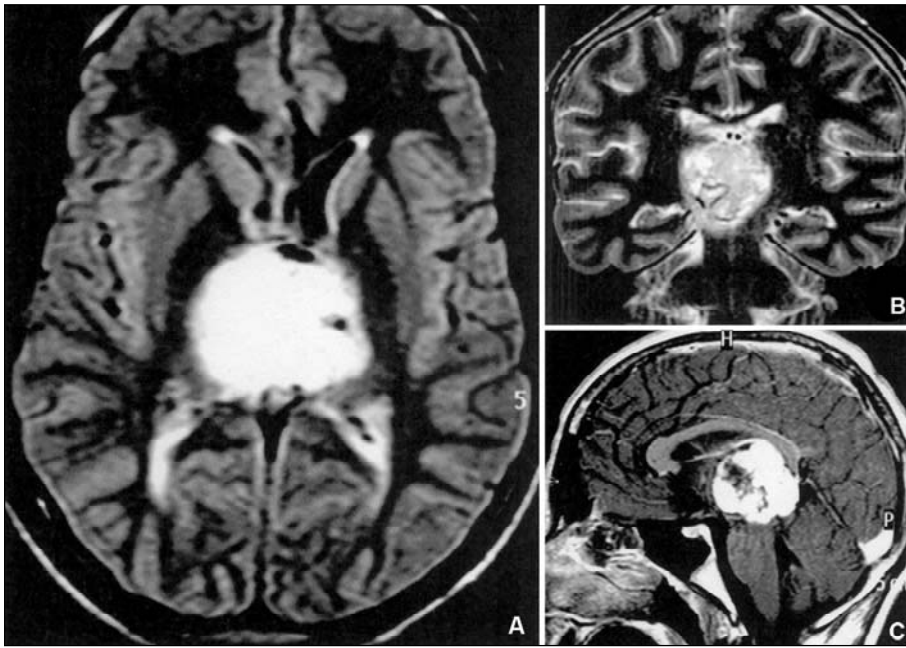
(A) Coronal T2-weighted image demonstrates a midline mass with heterogeneous high-signal. (B) FLAIR image shows a pineal region mass with high signal intensity, which is compressing both thalami and the third ventricle. (C) Coronal T1-weighted image after contrast administration reveals intense and heterogeneous lesion enhancement.
